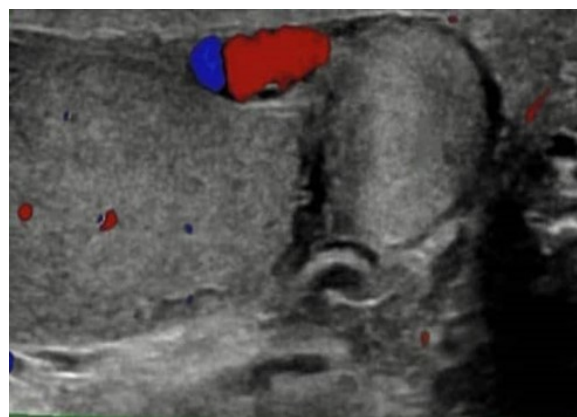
Doppler ultrasound image of the right extra testicular mass showing flow in the right testis but no flow in the extra testicular mass (courtesy of Alpha Clinics)
